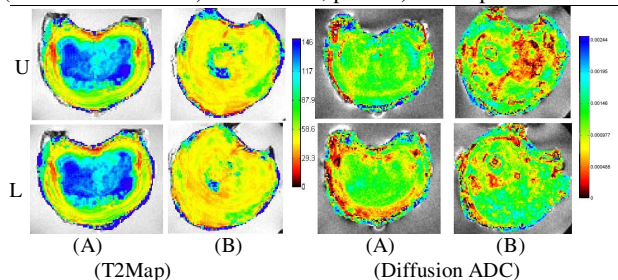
T2Map and diffusion weighted (trace values $[(\sum D_{x,z})/3]$) MR images of 39 (A) vs. 72 years (B) old discs under Unloaded vs. Loaded.
